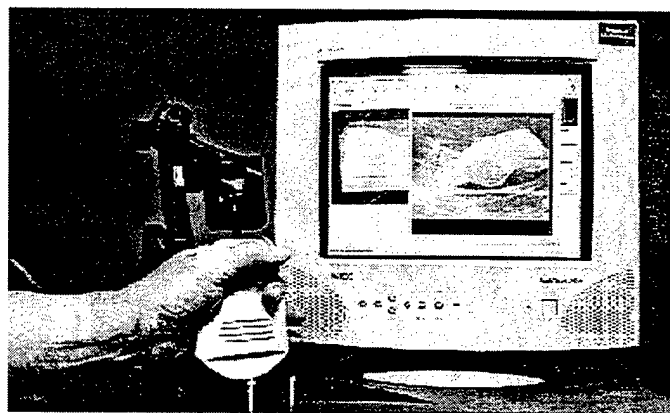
Closeup of the Virtual Ultrasound Probe and diagnostic workstation display.
